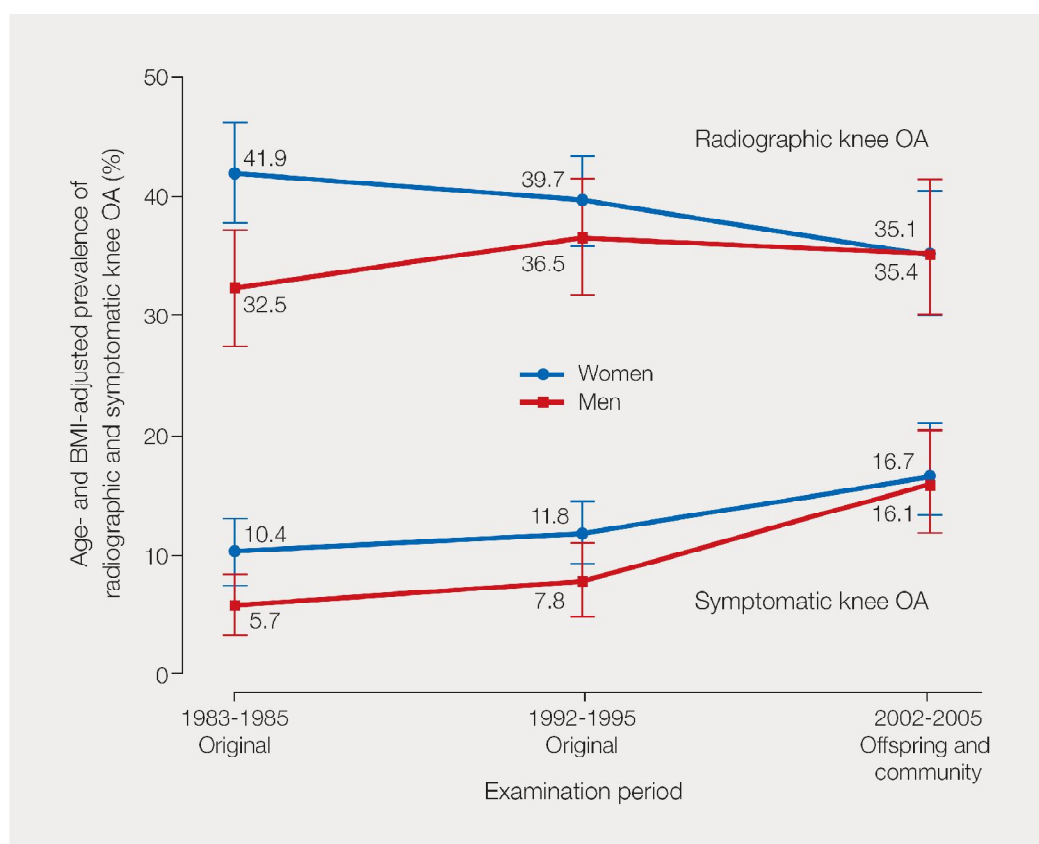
Varying prevalence of radiographic and symptomatic knee osteoarthritis over a 20-year period among participants in the Framingham Osteoarthritis Study.<sup>9</sup>
